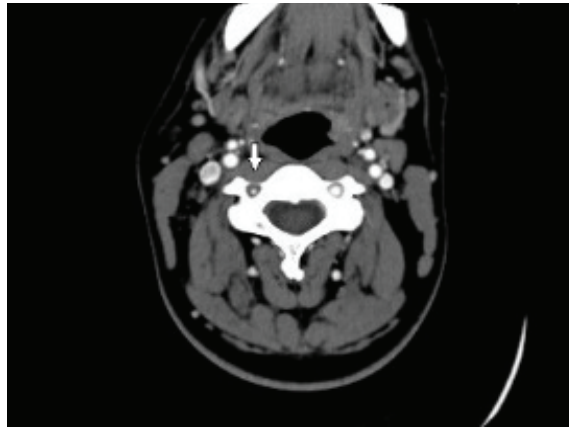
CT angiogram showing right non-dominant vertebral artery.
